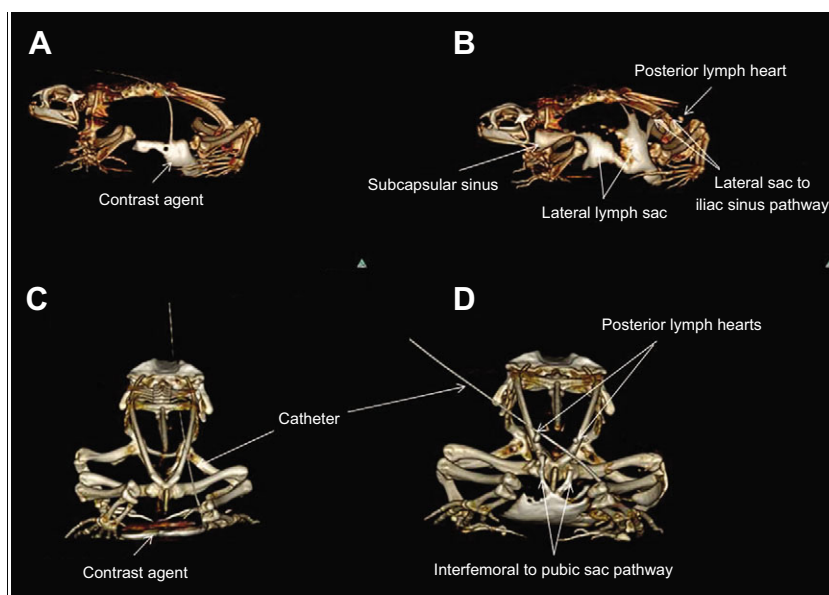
Movement of iodinated contrast solution injected into the left lateral lymph sac and interfemoral lymph sac over time in two cane toads. (A) Computed tomography (CT) 9 min after injection of a 0.5 ml bolus of contrast solution into the left lateral lymph sac. The contrast-filled catheter is also visible. (B) CT 39 min after injection of contrast solution. Contrast agent moved in anterior, dorsal and posterior directions. Movement of contrast agent from the point of origin occurred in the anterior direction from the lateral sac to the subscapular sinus; movement occurred dorsally within the lateral lymph sac; and there was a pathway from the lateral sac to the posterior lymph heart via a small channel through the iliac sinus. (C) CT 1 min after injection of a 0.5 ml bolus of contrast agent into the interfemoral sac. (D) CT 30 min after injection of contrast agent. The contrast agent moved in a ventral to dorsal direction through an interfemoral sac to pubic sac pathway where it filled the posterior lymph hearts.
